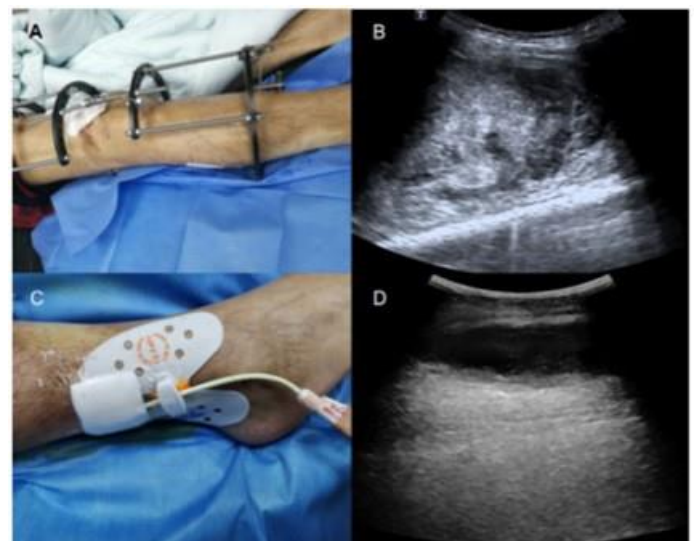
The bone traction device was riveted in the patient's right leg (A). Ultrasound examination revealed a heterogeneous echo mass on the lateral muscles of right calf (B). A 12F drainage tube was inserted into the hematoma (C). Five days after drainage and urokinase lavage, ultrasonography showed that the volume of hematoma decreased significantly (D).
